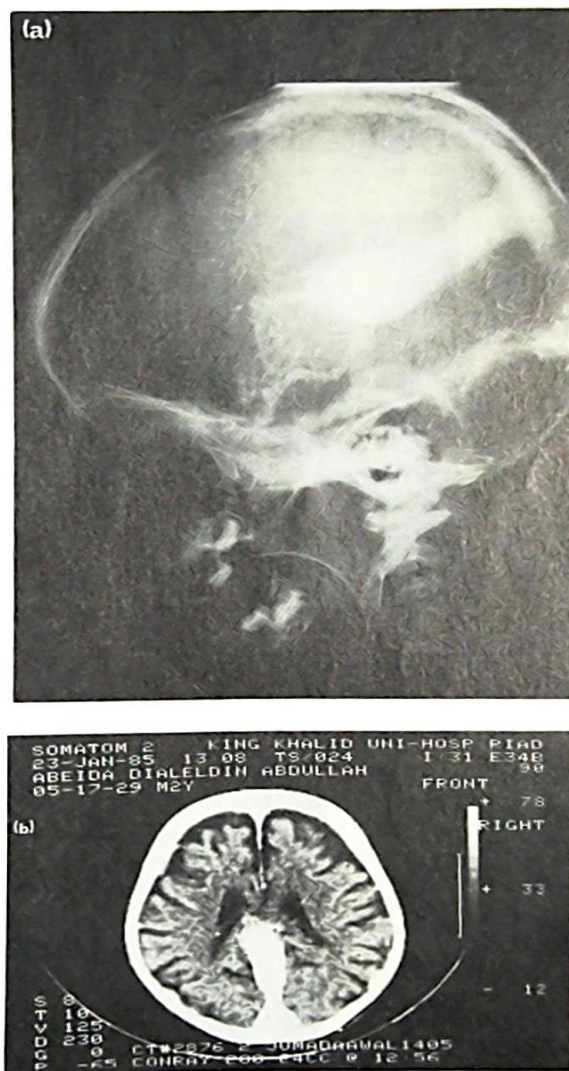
(a) Aneurysmal dilatation of the vein of Galen with a dilated straight sinus fed by numerous arteries arising from the middle cerebral artery. (b) Enhanced CT of the brain showing aneurysm of the great vein of Galen draining into a distended straight sinus and torcula. Note the atrophy of the brain, especially frontally.
